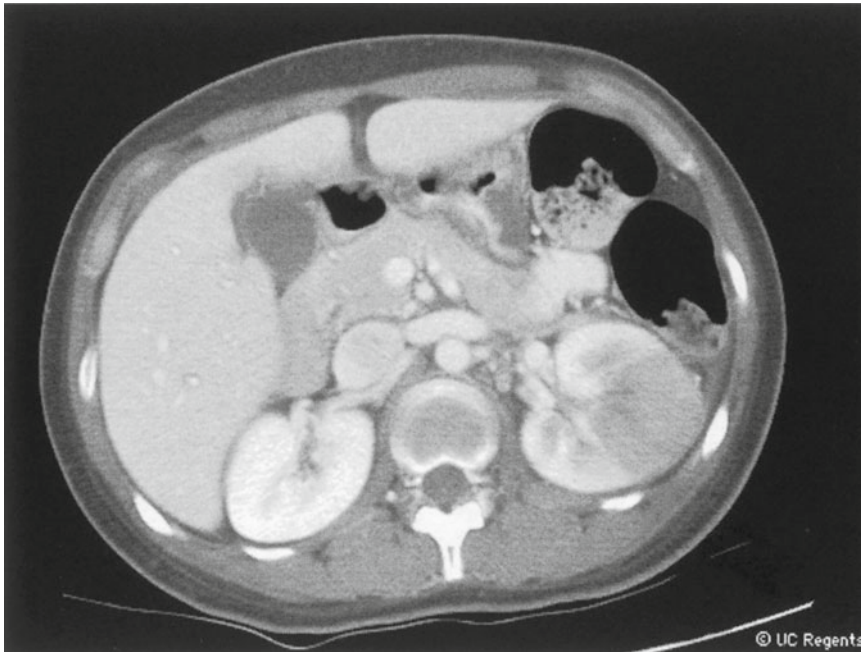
Contrast-enhanced CT demonstrating evidence of left pyelonephritis. Note the enlarged renal contour, compared to the right side, as well as the wedge-shaped area
